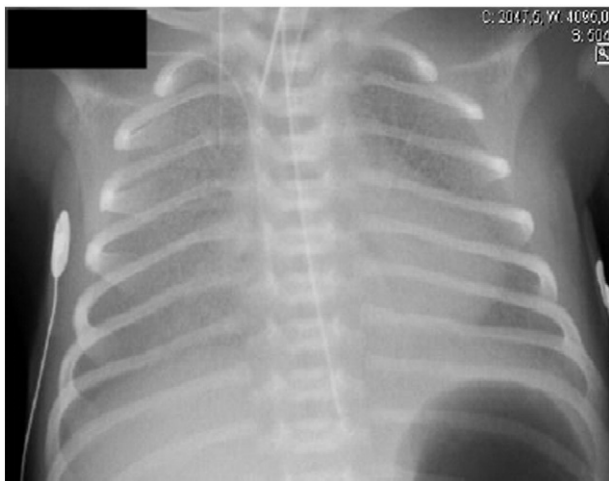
Chest radiograph at day 4 of life.
